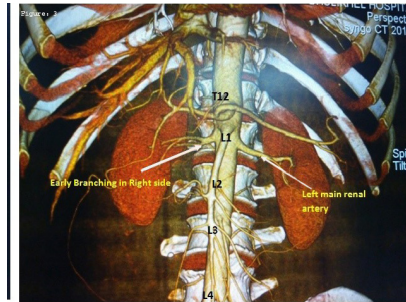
CT angiographic image showing the presence of early branching in the right renal artery
